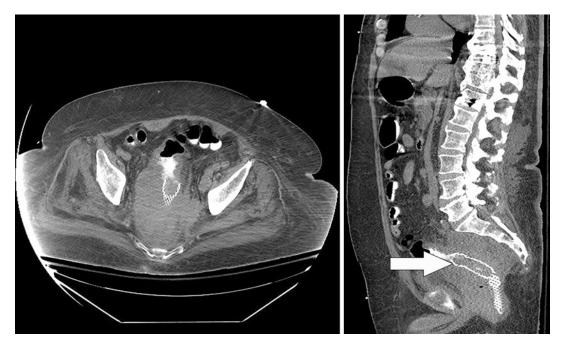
A 67-year-old male with obstructing rectal cancer, palliated by rectal stent (arrow), as seen on contrastenhanced CT
